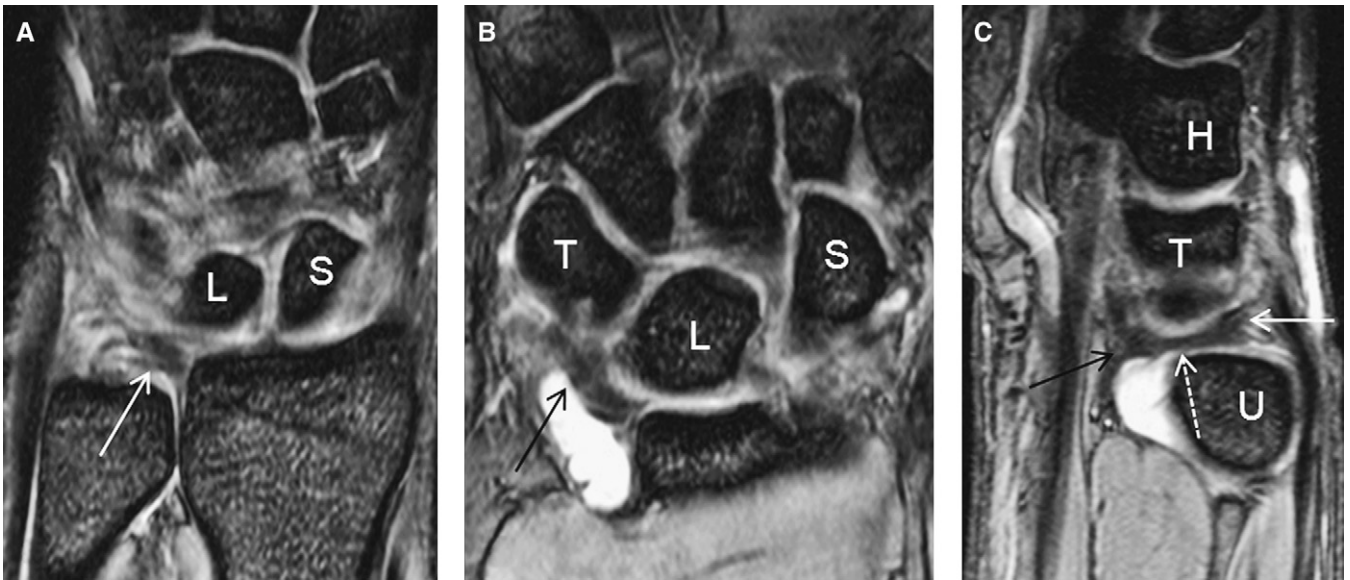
Distal radioulnar joint. Coronal T2-weighted gradient recalled echo (GRE) dorsal (A) and volar (B), sagittal T2-weighted GRE (C), demonstrating the dorsal radioulnar ligament (white arrows), volar radioulnar ligament (black arrows), triangular fibrocartilage proper (dotted white arrow). L = lunate; S = scaphoid; T = triquetrum; H = hamate; U = ulna.
